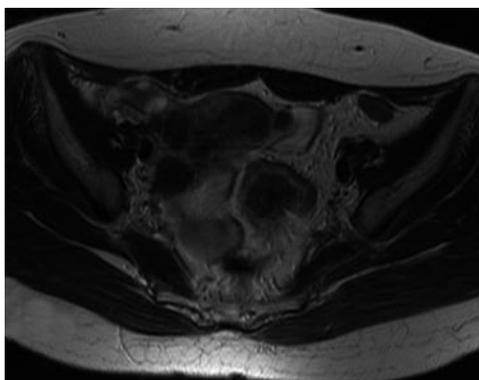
MRI (T2 weighted image) shows a sigmoidal tumor lesion with low signal intensity.
